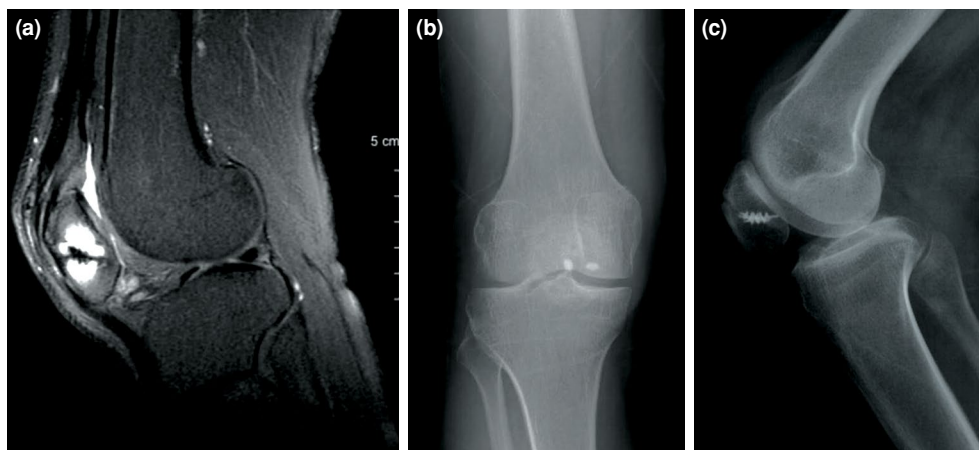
Postoperative control MRI at six years of follow-up. (a) Sagittal MRI. (b) Anteroposterior and (c) lateral radiographs of the knee. Graft incorporation is evident. The patient had patella baja not interfering with physical activities.
